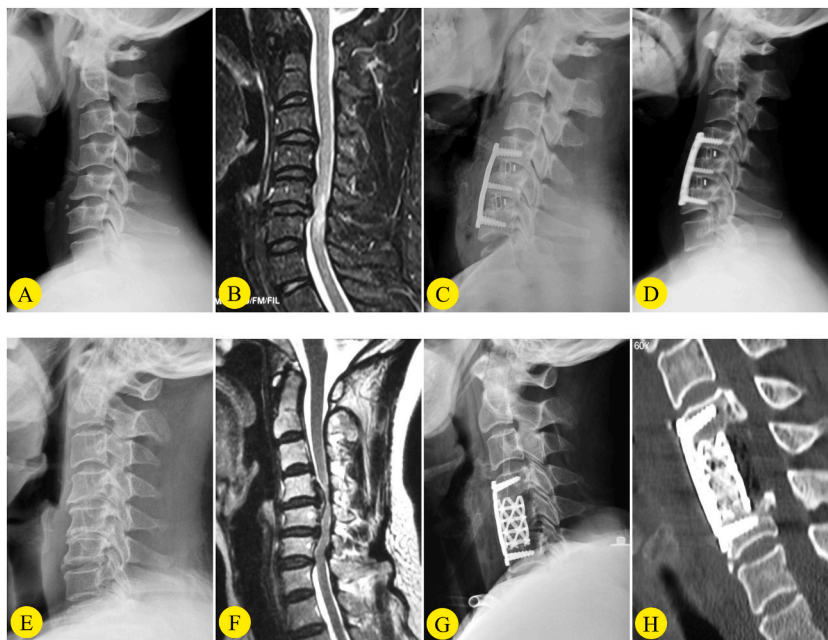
A 53-year-old man who underwent ACDF. A: The preoperative lateral X-ray shows LKA, C2–7 Cobb angle, T1 slope, and C2–7 SVA were 16°, 10°, 14°, and 11 mm, respectively. B: Preoperative MRI showing C4–6 spinal cord compression combined with kyphosis. C: A postoperative lateral X-ray showing ACDF. D: On the lateral X-ray of 2.5 years after surgery, the LKA, C2–7 Cobb angle, T1 slope, and C2–7 SVA were –8°, 9°, 18°, and 21 mm, respectively. A 60-year-old woman who underwent ACCF. E: The preoperative lateral X-ray shows LKA, C2–7 Cobb angle, T1 slope, and C2–7 SVA were 19°, 11°, 15°, and 18 mm, respectively. F: Preoperative MRI showing C4–6 spinal cord compression combined with kyphosis. G: A postoperative lateral X-ray showing ACCF. H: On the CT image of 3 years after surgery, the LKA, C2–7 Cobb angle, T1 slope, and C2–7 SVA were –2°, 4°, 19°, and 27 mm, respectively.
